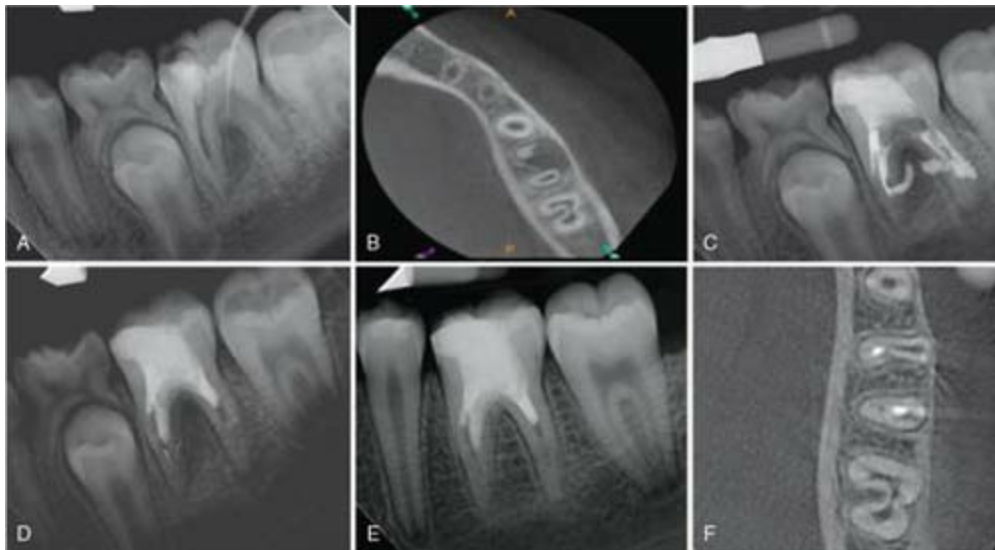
An 11-year-old female was referred for evaluation of tooth #19 diagnosed with pulp necrosis and chronic apical abscess traced with a gutta-percha cone as seen in the periapical (PA) radiograph (A). A small-volume CBCT revealed resorption in mesial and distal roots (B). The canals were disinfected and medicated with Vitapex (C). Four weeks later, the patient was asymptomatic and tooth #19 and the sinus
